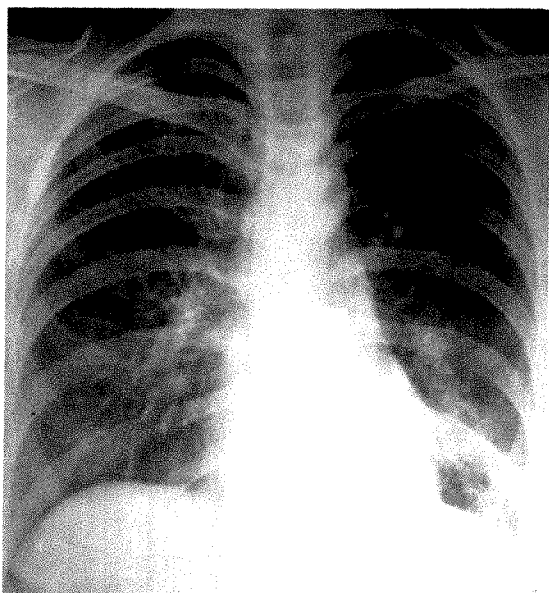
Posteroanterior roentgenogram shows acute left lower lobe pneumonia, which developed four months following the above procedures and cleared rapidly on antibiotic therapy leaving no residual.
